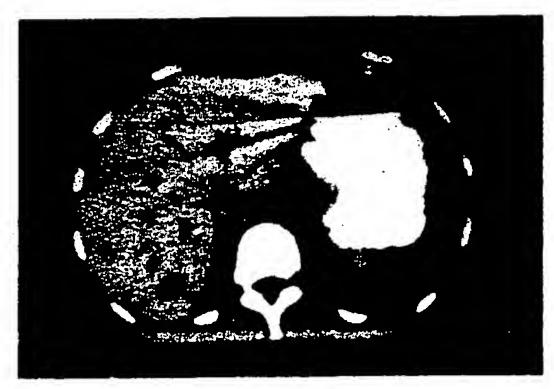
CT scan showing the liver with metastatis.
